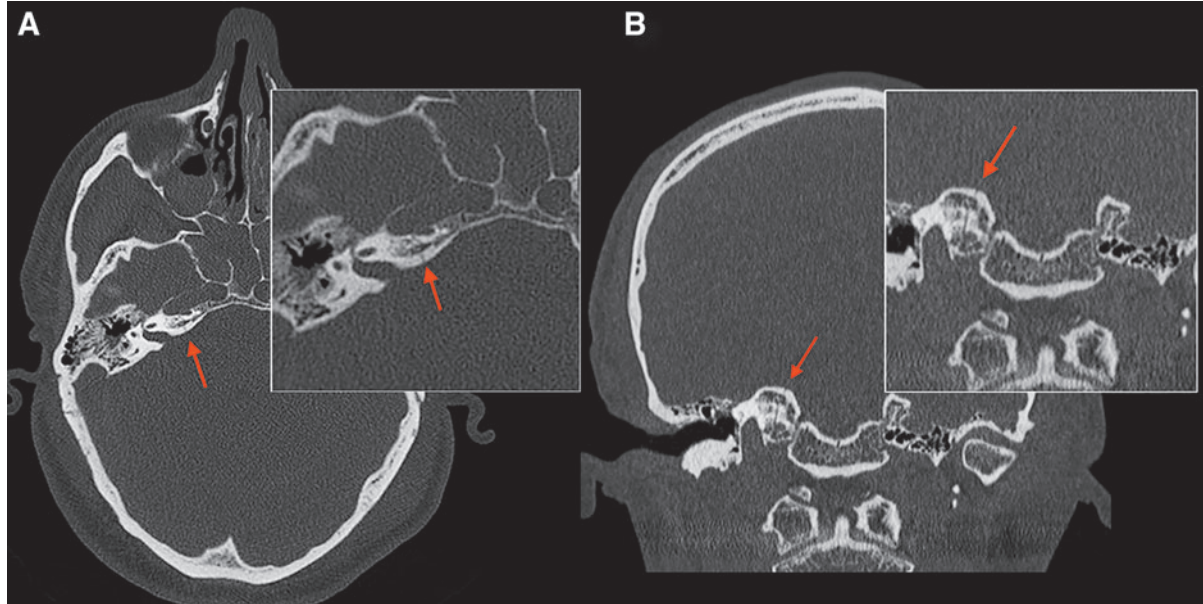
Axial and coronal non-contrast computed tomography images with bone window of a patient with skull base fractures. Fractures at the level of the skull base, especially in the sphenoid bone and the petrous part of the temporal bone, may be difficult to detect. (A) Shows a fracture at the level of the horizontal (arrow, A) and vertical segment (arrow, B) of the internal carotid artery (ICA) canal. It is crucial not to miss these fractures, as they can be associated with vascular dissection.
